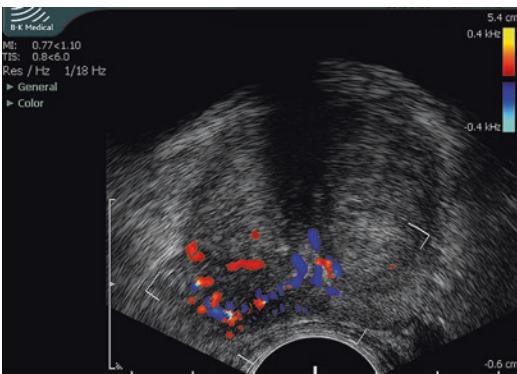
The use of echo-color Doppler during TRUS with the evaluation of the resistive index – RI – plays a fundamental role in the consideration of the severity of symptoms
